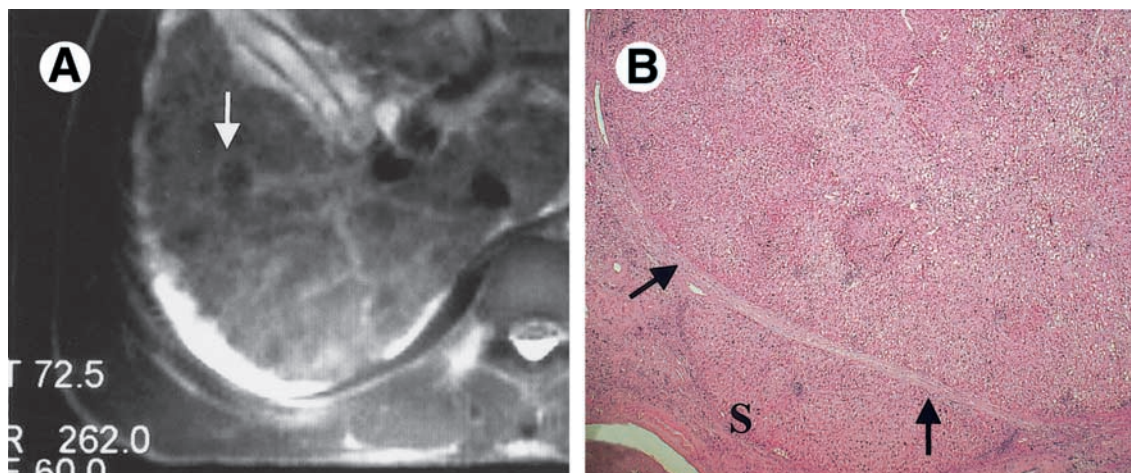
(A) A hypointense nodular lesion on the T2-weighted contrast-enhanced MR image. The lesion was correctly diagnosed as a DN. (B) The corresponding LGDN in the cirrhotic explant liver (arrows) is steatotic and paler than the surrounding regenerative nodules (S) and has a diameter of 1 cm. (Original magnification: [B] $\times 25$.)
